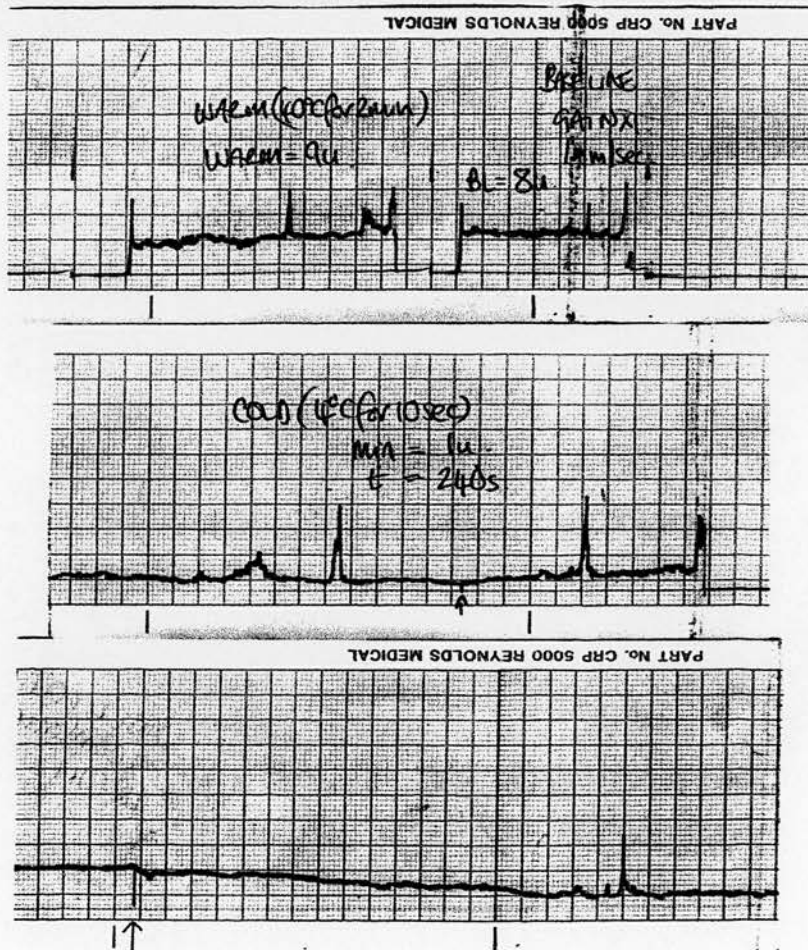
Printout from Laser Doppler Flowmeter (fingertip)
